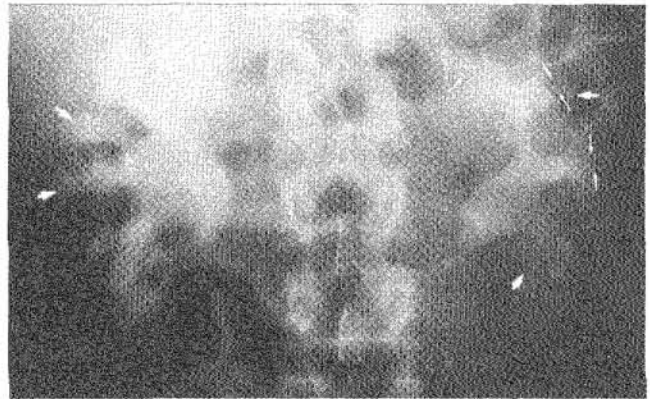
Same radiograph as Figure 1 with the addition of arrows. Multiple clustered calcifications are seen, resembling "bunches of grapes" (arrows)
